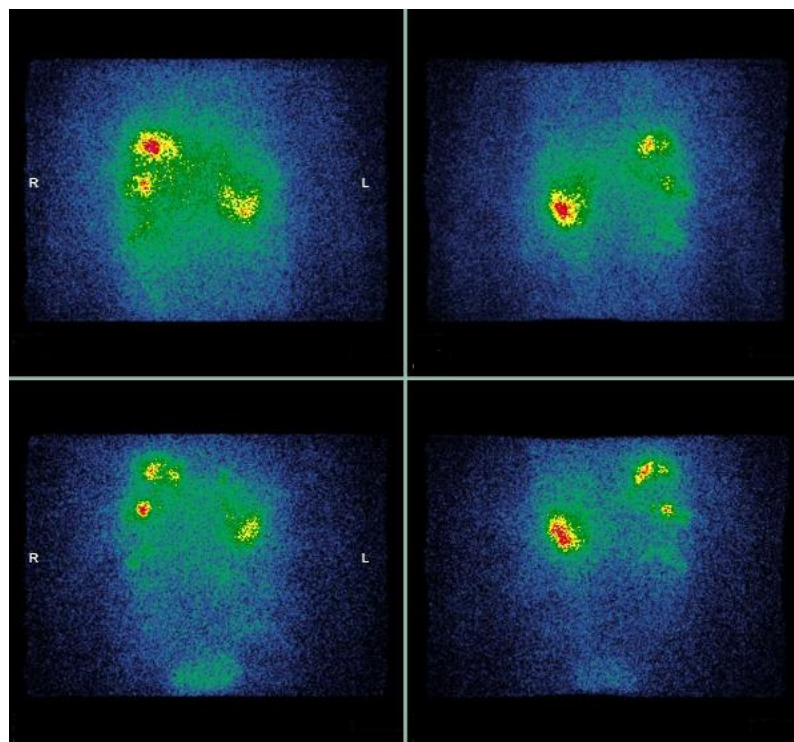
Iodine-123 MIBG scintigraphy findings showing abnormal uptake in left adrenal tumor and liver metastases
